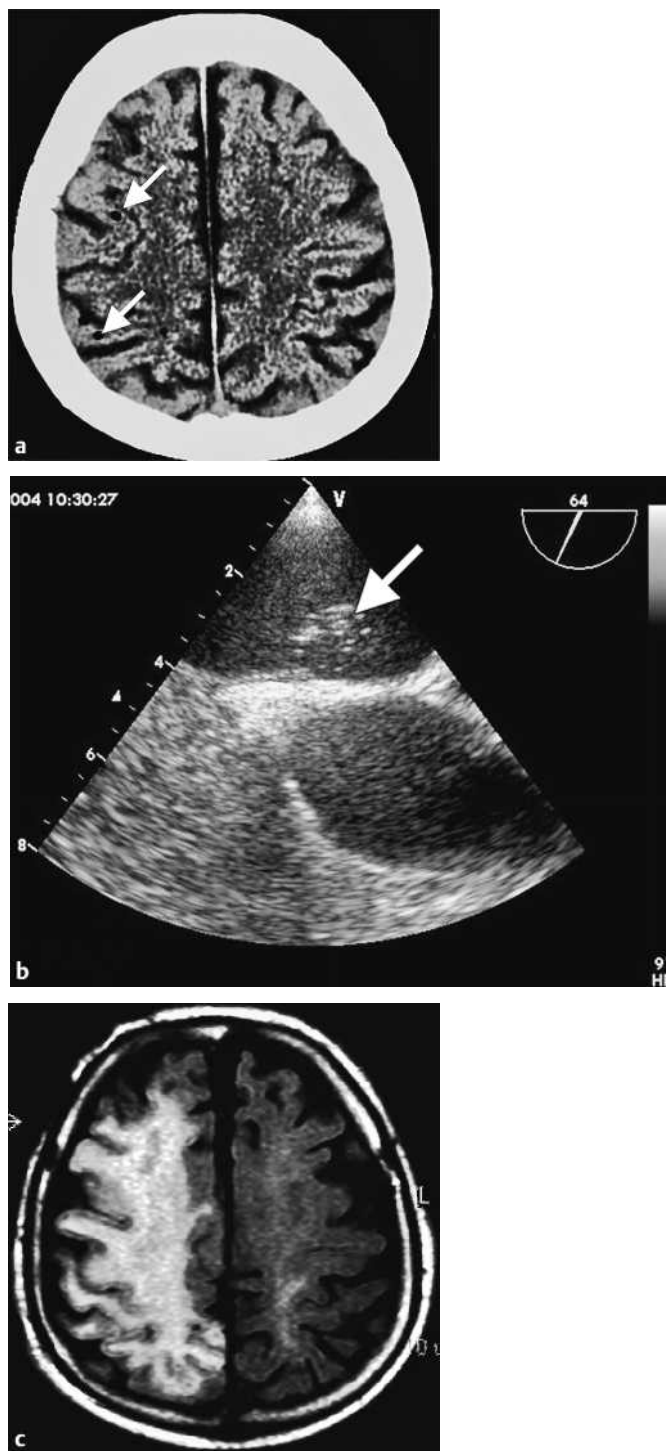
Patient 1. a Computed tomography showed air bubbles in the brain parenchyma (arrows). b Transesophageal contrast echocardiography demonstrated a patent foramen ovale with a spontaneous right-to-left shunt, shown by the bubbles of Echovist contrast (Schering, Berlin, Germany) entering the left atrium (arrow). c Magnetic resonance imaging with an axial FLAIR sequence 15 days after the air embolism showed edema of the right hemisphere.
